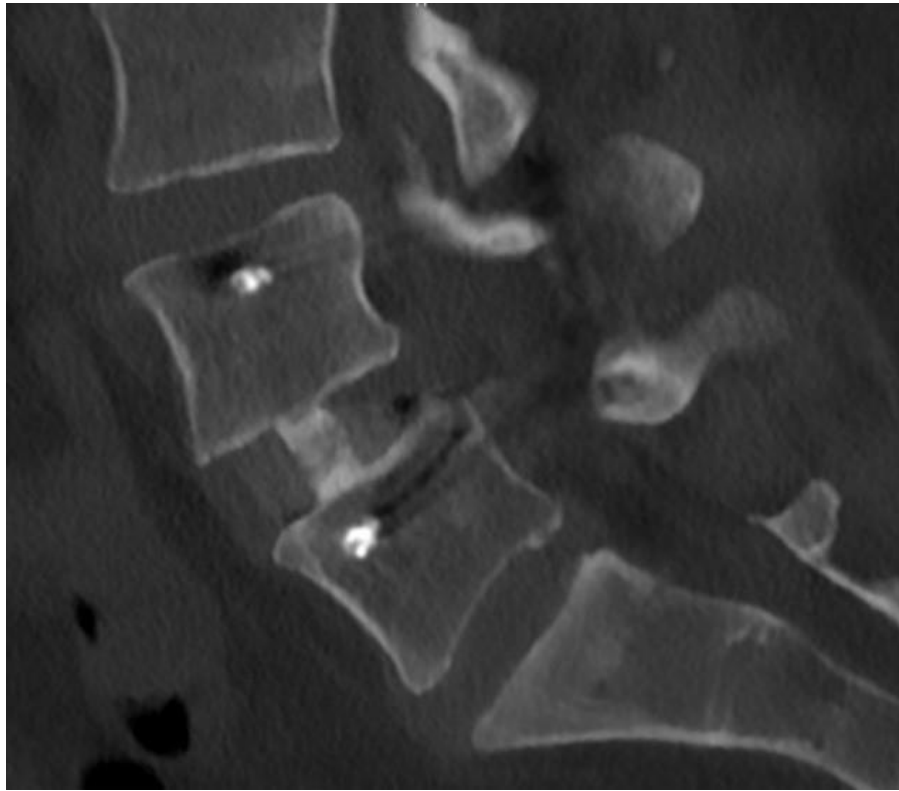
Sagittal computed tomography (CT) at 12-month follow-up demonstrating stable construct and stable spinal alignment with solid fusion at L4-L5.
